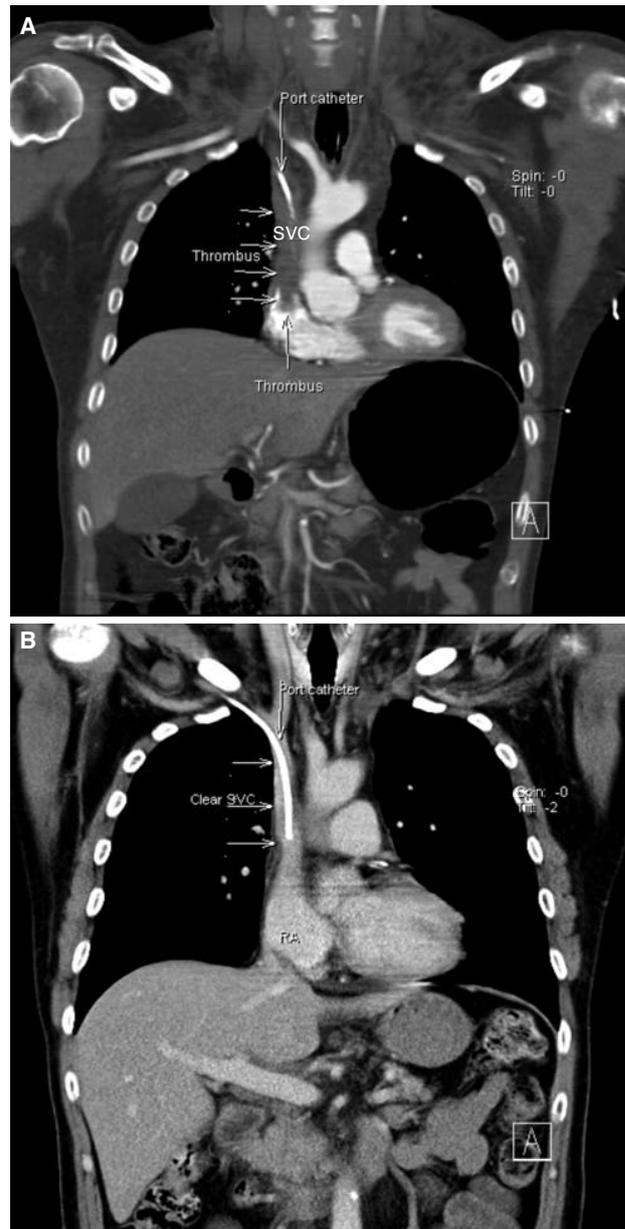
(A) Contrast computed tomography angiography showing massive thrombotic occlusion of the superior vena cava (SVC). (B) Complete resolution of massive thrombosis following fibrinolytic therapy. SVC: Superior vena cava; RA: Right atrium.
